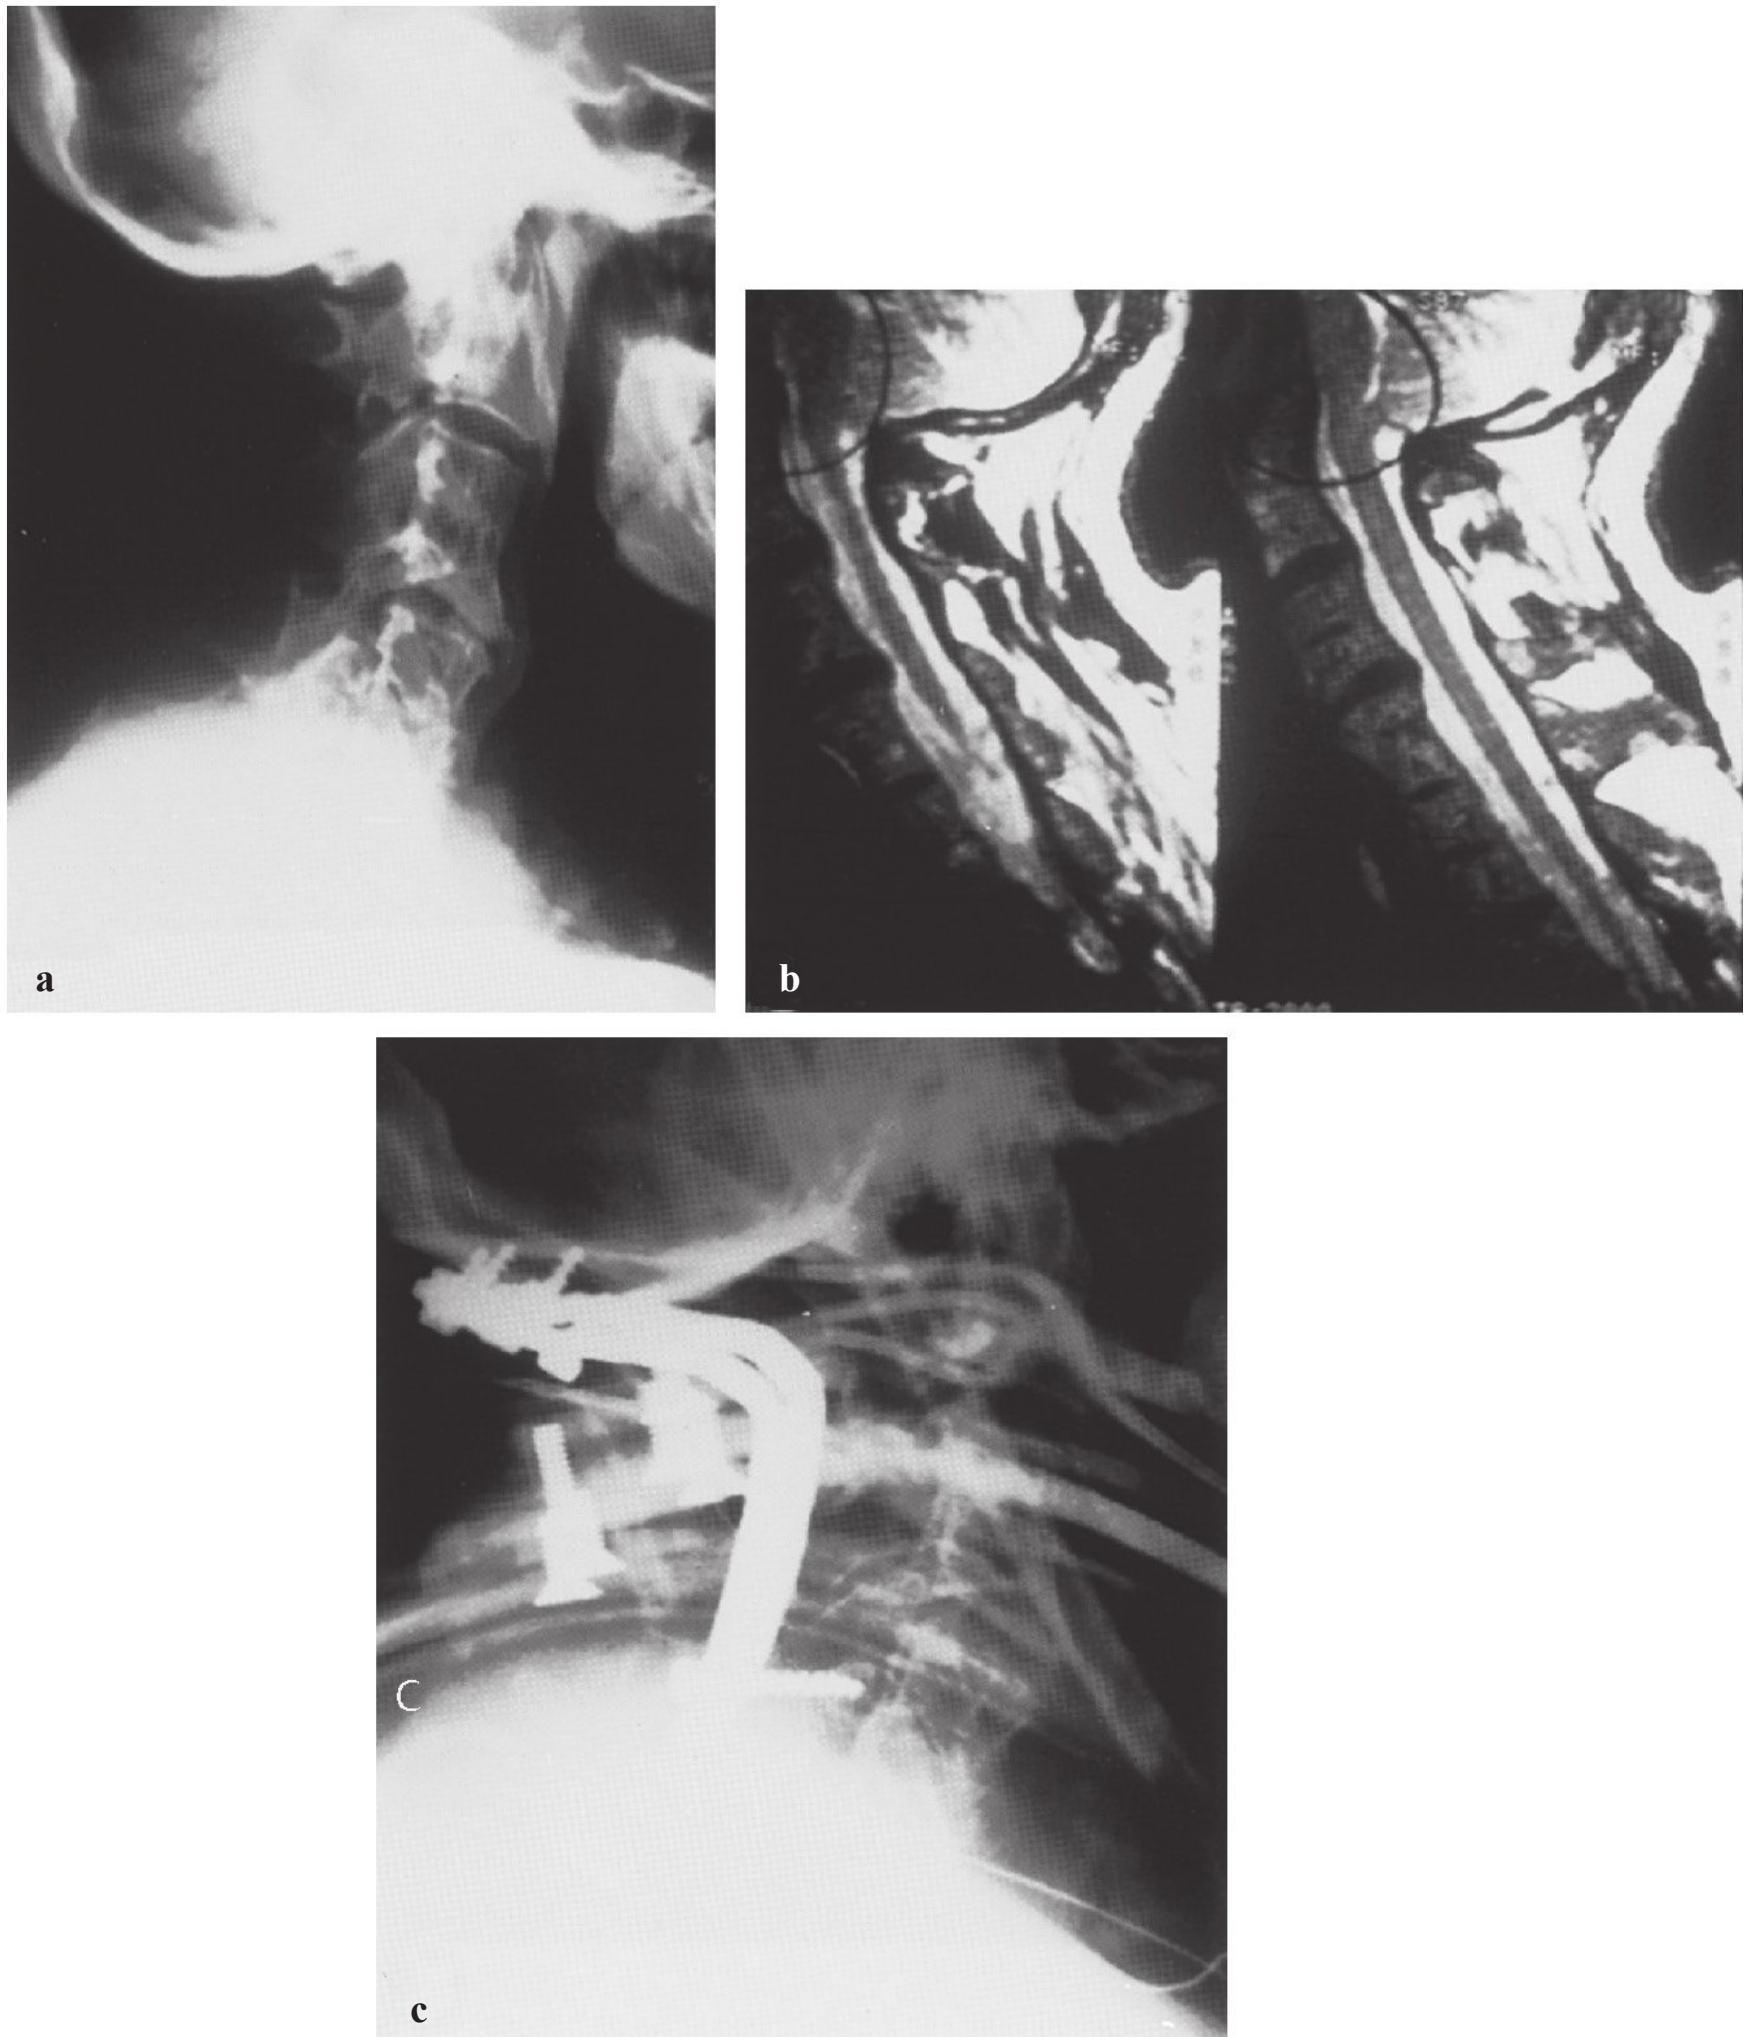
A 55-year-old man with Klippel–Feil syndrome and basilar invagination. The patient presented with severe neck pain and headache. (a) Lateral radiograph showing congenital fusion between C3–C4 and C5–C6. (b) Magnetic resonance imaging also shows the congenitally fused vertebrae with disk degeneration at C4–C5. Basilar invagination is noted as well. (c) Postoperative radiograph showing an occiput–C6 fusion with plate–screw fixation.
